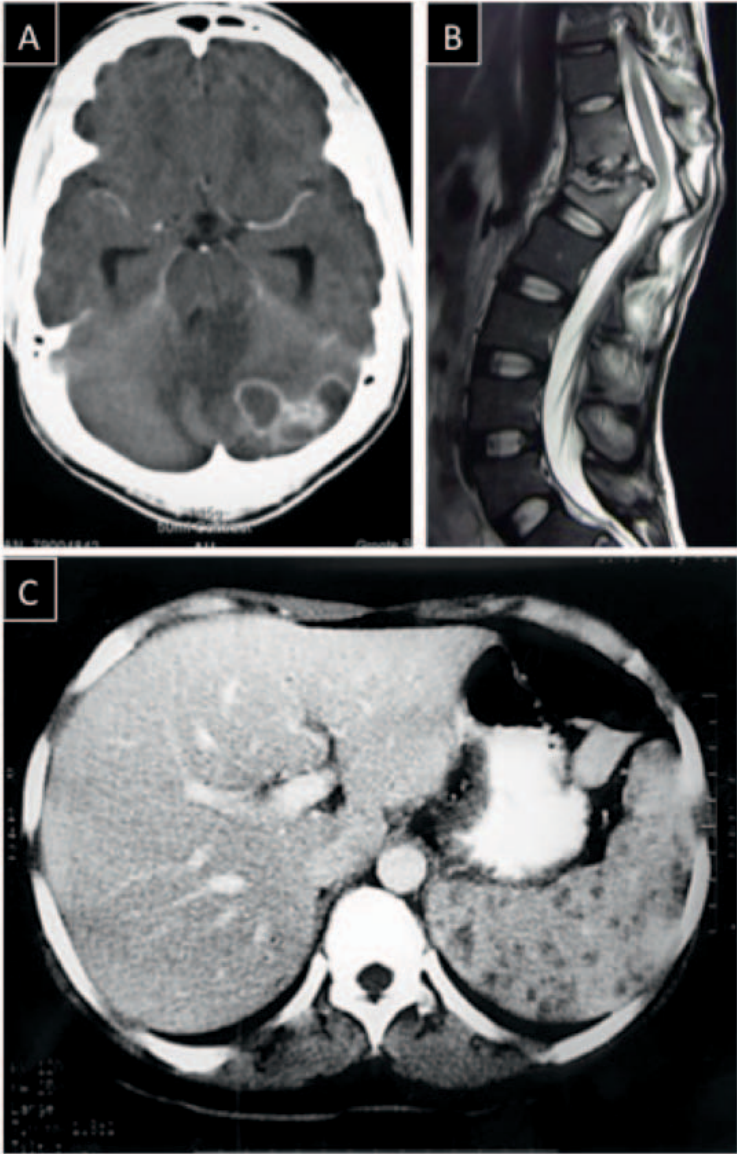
Cranial CT showing multiple ring-enhancing space-occupying lesions (A). Potts disease of the spine showing destruction of the disc space (B) and abdominal CT scan showing multiple splenic micro-abscesses
